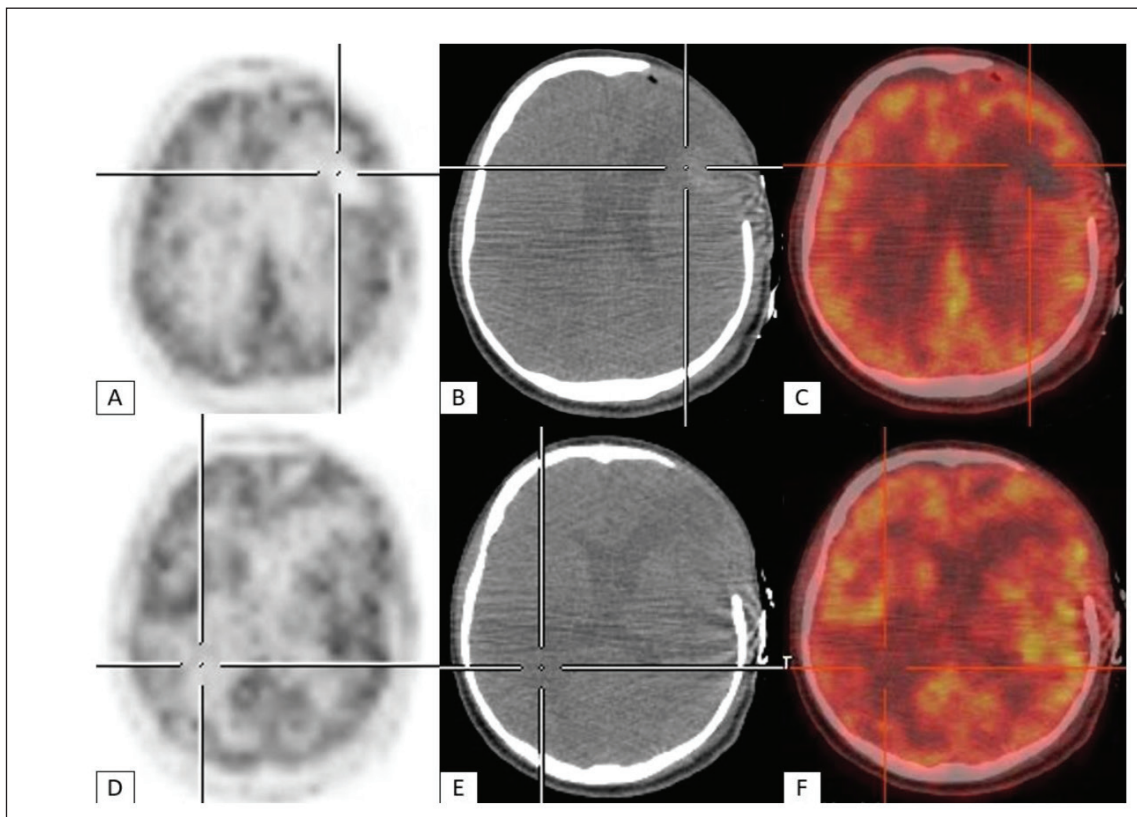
Axial 18F-FDG PET, CT, and Fused PET/CT brain images revealing a metabolic defect in the postoperative intra-parenchymal edema-hemorrhagic alterations in the left fronto-parietal region and a non-hypermetabolic subgaleal collection in the left frontoparietal area (A, B, C), associated with slight hypometabolism in the right parietal expansive lesion process (D, E, F).
